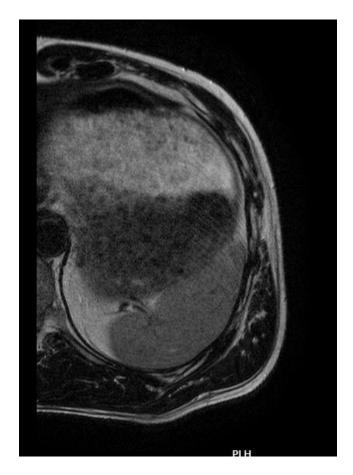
MRI Axial view- Bulky inferior fibres of left serratus anterior muscle with ill defined hyper intensities
